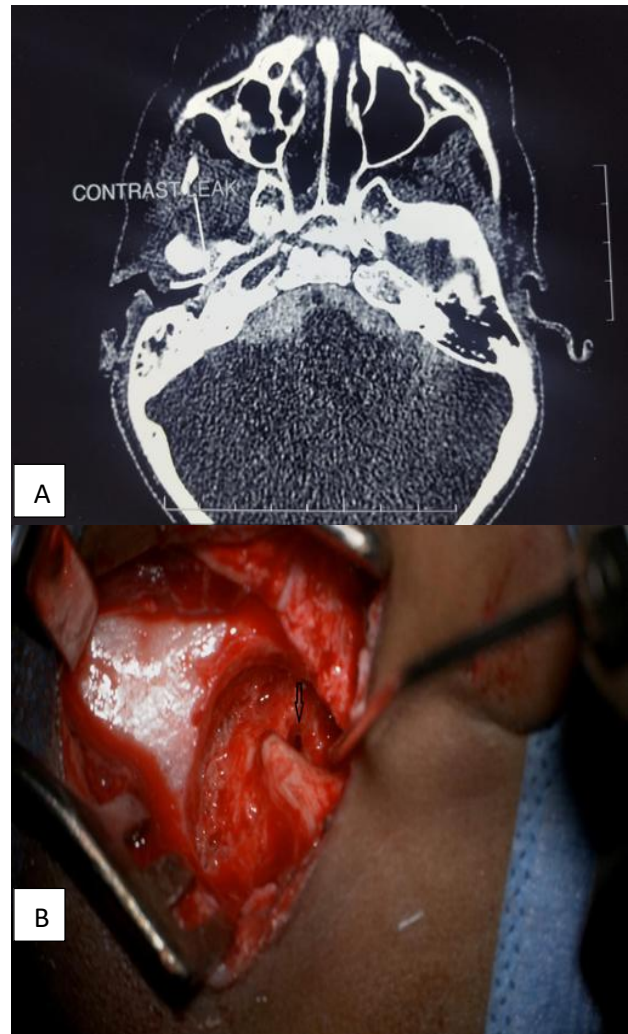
Figure (A and B): A) showing the CT cisternogram picture where the dye leak is seen in the middle ear and B) showing the intra operative defect in the oval window (black arrow).
